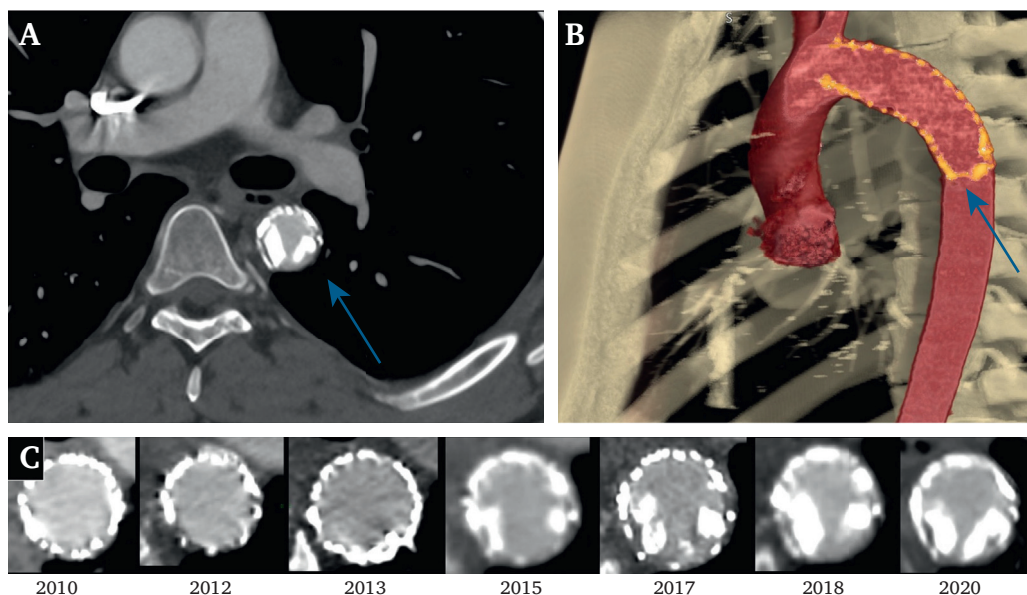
Follow up computed tomography angiography of the 35 year old patient. (A) A transverse section of the thoracic endovascular aortic repair (TEVAR) at the site of the in stent stenosis, highlighted by the blue arrow. (B) The frontal plane of the 3D reconstruction at the site of the device and the in stent calcifications are highlighted by the blue arrow. (C) The transverse sections of the distal end of the TEVAR over the years, with the increasing burden of calcification.
